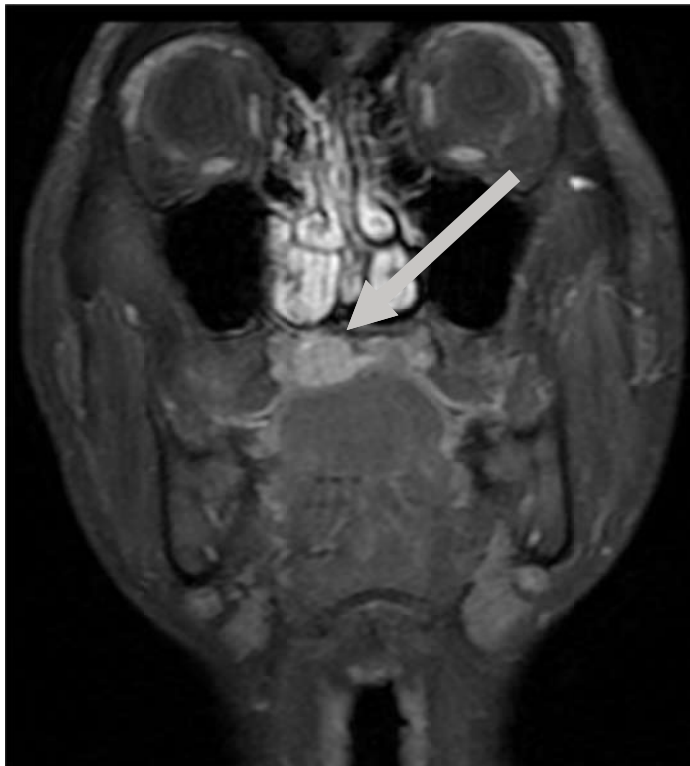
A tumor mass with enhancing density about 2 x 2 cm noted at right hard palate on the coronal section of MR image.
